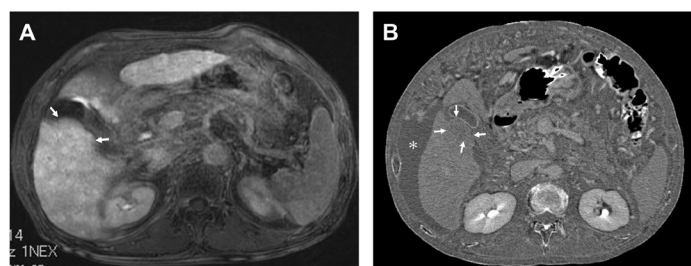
A 61-year-old man with alcoholic liver disease (ALD). Child-Pugh grade/score was A/5, and modified albumin-bilirubin grade/score was 1/-3.0. A slight nodularity (arrows) is appreciable at the gallbladder fossa (GBF). GBF nodularity grade 2 was assigned. (A) Hepatobiliary phase image of gadoxetate-enhanced MRI. GBFN exhibits almost similar signal intensity as the surrounding background liver (arrows). (B) Extracellular volume fraction (ECV) map calculated from CT obtained 4 months after MRI. There is apparent increase in the volume of ascites (*) as compared to 5A. ECV of GBFN was 26%, whereas that of background liver (average of anterior, posterior, and medial segments, not shown) was 45%. ECV ratio was 0.59. Note GBFN of apparent low ECV value (arrows).
